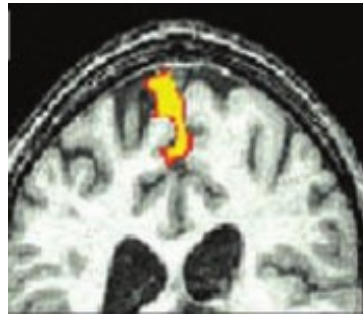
MR image (coronal plane) of the activated region in the precentral gyrus, induced by active movements in the ankle (dorsiflexion), showing the deep localization of the leg-representation inside the motor homunculus (Kocak et al., 2009).
